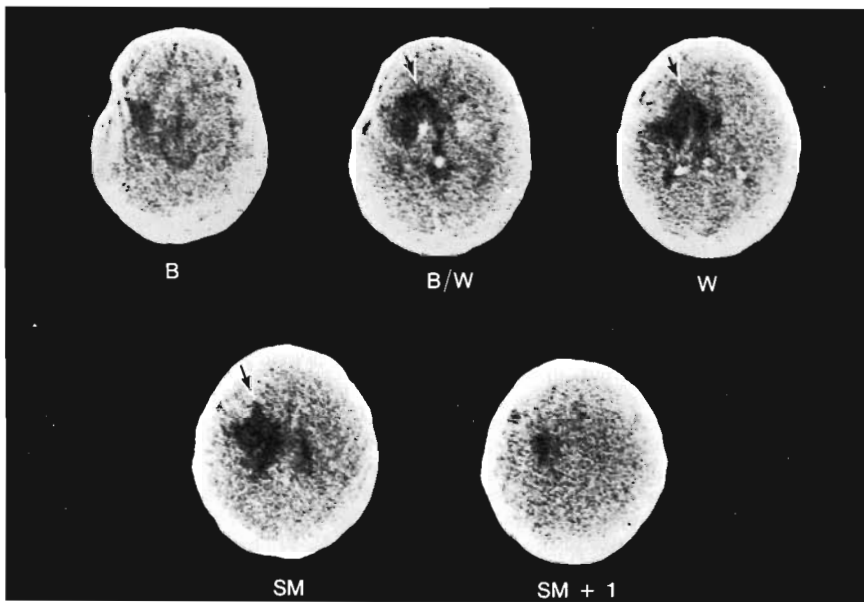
Computed tomographic scan (case 9) done 26 months after stroke. Subcortical lesion site with occlusive-vascular etiology is capsular/putaminal with both anterior-superior and some posterior extension. Frontal lobe lesion of periventricular white matter extends anteriorly beyond frontal horn, including fibers leading to genu of corpus callosum (arrows).
